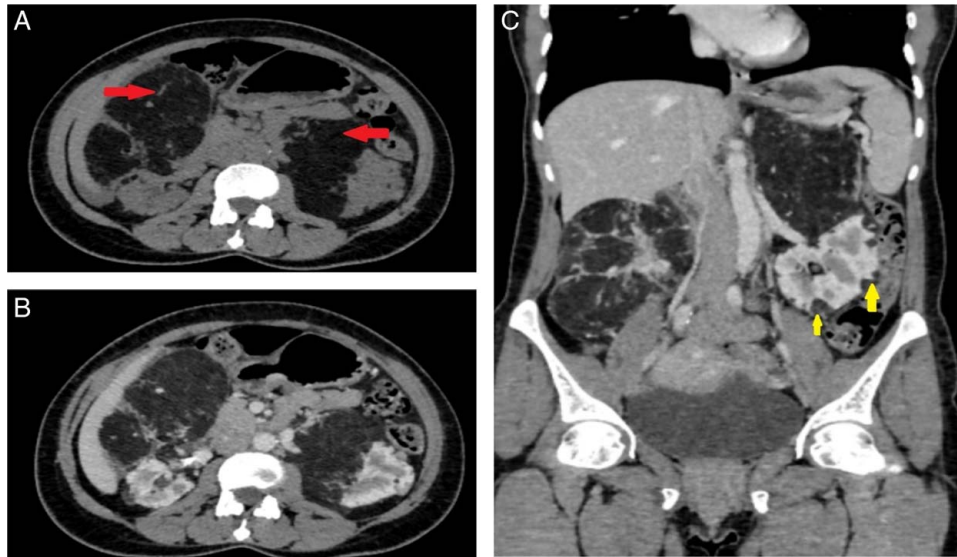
Noncontrast computed tomography (A) and contrast-enhanced computed tomography (B) images of the abdomen in axial plane shows well-defined large, lobulated, exophytic, heterogeneous fat-attenuating mass lesions arising from bilateral kidneys (inter/lower pole of the right kidney and upper pole of the left kidney; denoted by red arrows in A and B), in keeping with renal angiomyolipomas. Contrast-enhanced computed tomography (C) images of the abdomen in coronal plane shows multiple other fat-attenuating lesions in the left kidney (yellow arrows in C).
